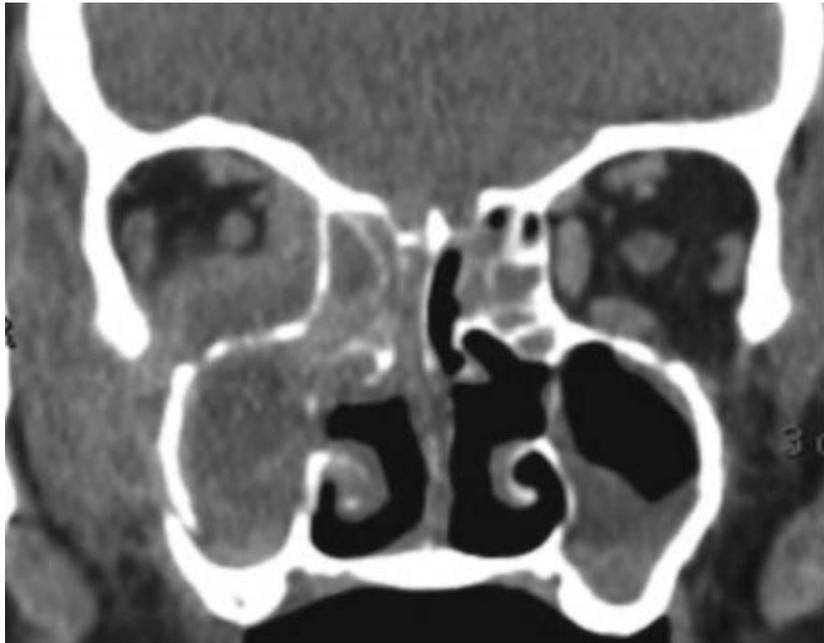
Mycetoma: The CT demonstrates expansion of the left infundibulum by a soft tissue lesion containing foci of calcification (*arrow*) (Raghavan et al., 2014).
